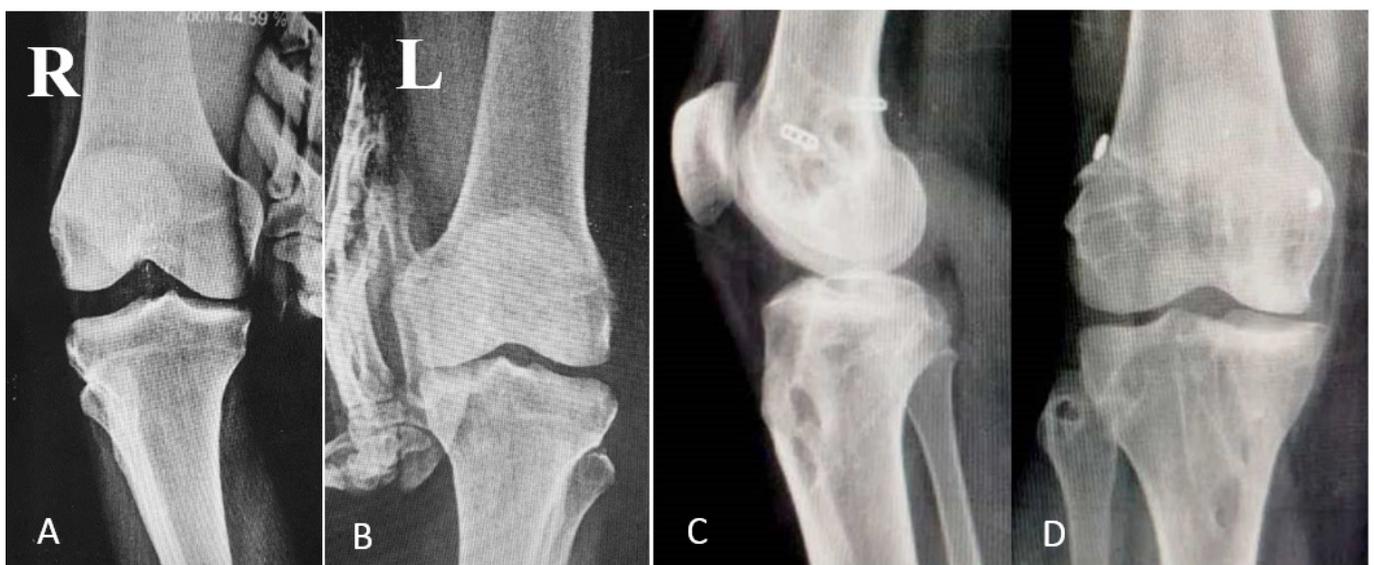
A and B) Varus stress radiography at 20 degrees in the right and left knees with right PLC, ACL, and PCL injury; C and D) One-year radiography after PCL, ACL, and PLC reconstruction.
